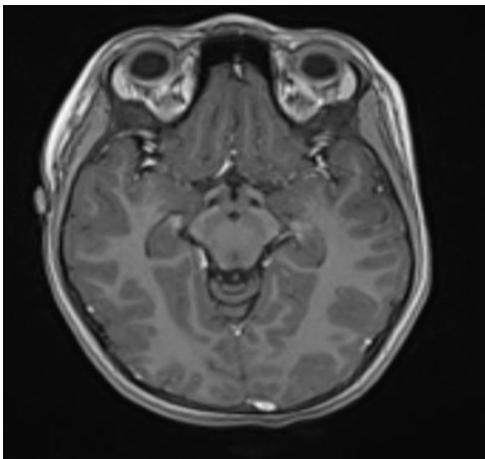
Mild enhancement was seen on post contrast FLAIR.
